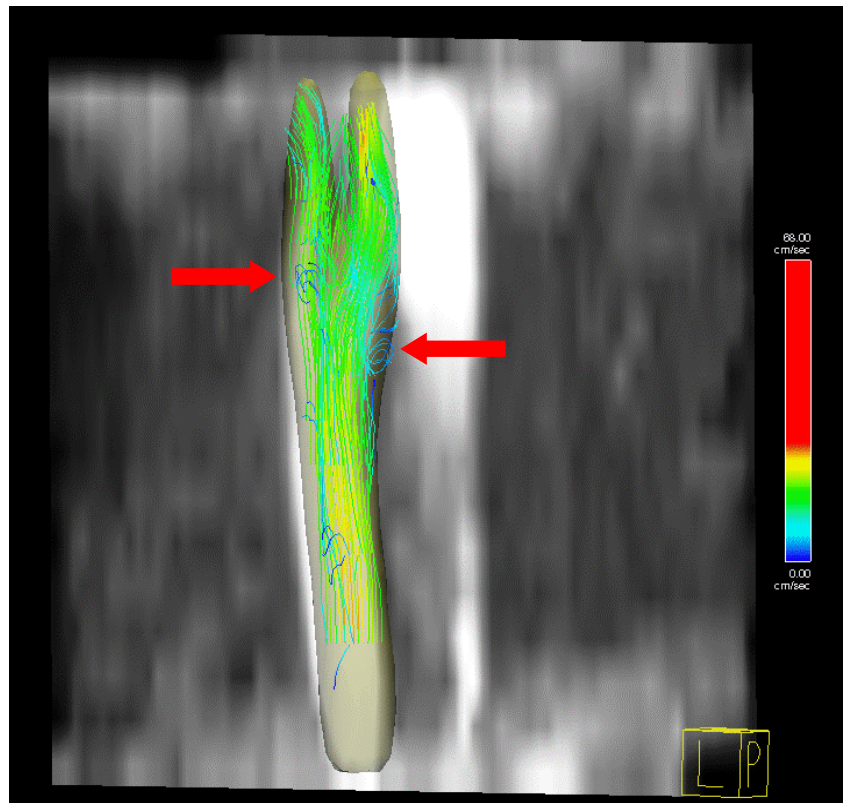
4D PC-MRI flow vector mapping for the right side carotid bifurcation in a healthy volunteer subject. Insets on the right hand side show the flow in cross section with reasonably uniform flow in the common carotid, bottom, flow directions beginning to separate in the carotid bulb, middle, and separation of flow with an indication of spiral flow post-bifurcation, top.
